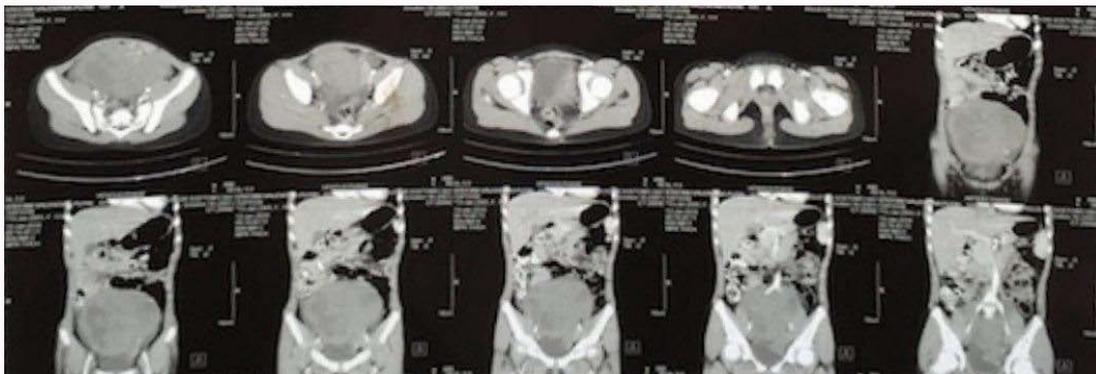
Abdominal CT showed mass with in abdominal and pelvic cavity.
